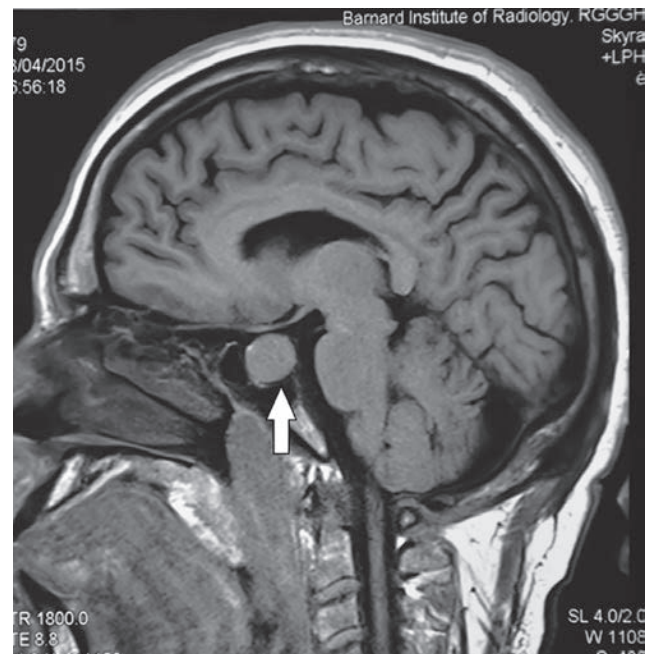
MRI brain. T₁-weighted image - Sagittal section. Well-defined isointense oval-shaped lesion of size 2 × 1.6 cm in the sellar region (arrow). Pituitary macroadenoma.
